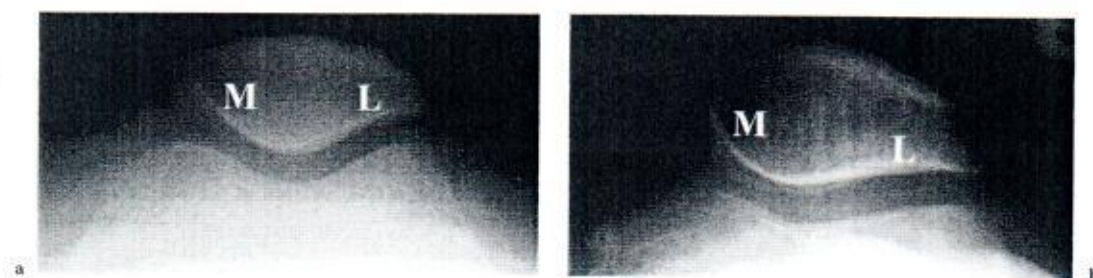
Axial radiographic views of two patellofemoral joints. Wiberg type I (a) is rare and the medial (M) and lateral (L) facets are almost equal in size. Wiberg type III (b) has a large lateral (L) and a small medial (M) facet and is commonly associated with a large sulcus angle. Type II, the most common type, is shown in Fig. 13.1
